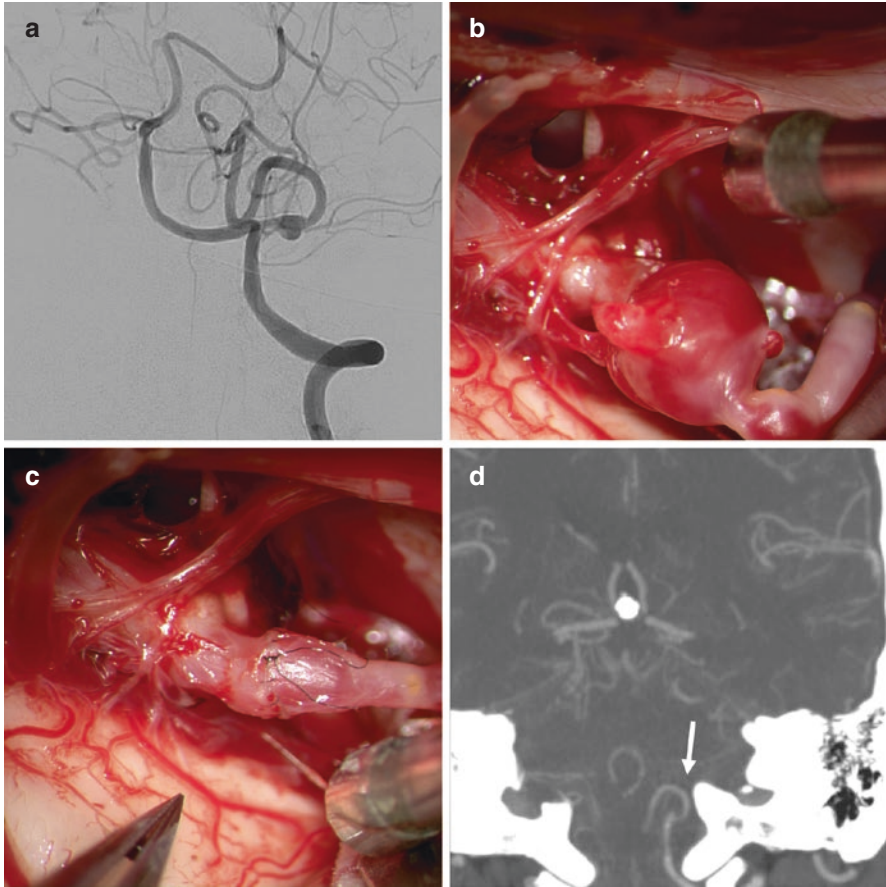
A patient presenting with subarachnoid hemorrhage was found to have a fusiform aneurysm at the junction of the p1 and p2 segments of the left PICA (a). A far-lateral craniotomy exposed the aneurysm (b). An undiseased segment of PICA was identified proximal to the aneurysm without associated perforators, enabling aneurysm excision and end-to-end reanastomosis (c). Postoperative CTA demonstrated patency of the bypass and confirmed complete excision of the aneurysm (d, arrow). Used with permission from Barrow Neurological Institute
